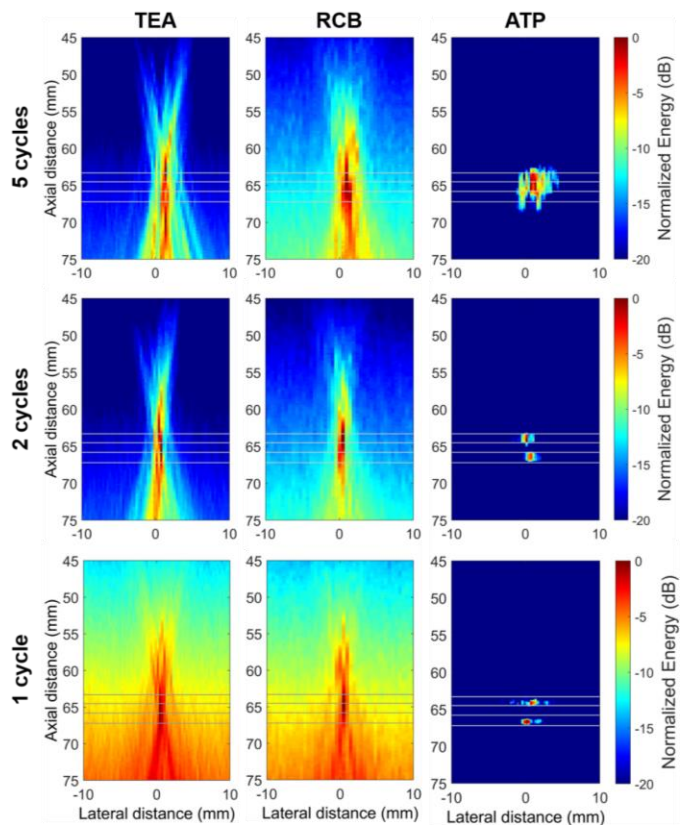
In vitro passive acoustic energy maps of microbubbles within two thin tubes exposed to 5-, 2- and 1-cycle wavelets. Microbubbles were injected through two thin silicone tubes (0.28 mm internal diameter and 0.61 mm external diameter) at approximately 2.5 mm axial separation and sonicated by 1-MHz center frequency pressure cycles with a beam focus at the axial midpoint of the two thin tubes. The resulting cavitation emissions were captured by a 128-element L7-4 linear array, which was embedded in the center of the ultrasound transducer. Axial distances refer to the distance from the linear array. The captured sensor data for 5, 2 and 1 pressure cycles was reconstructed independently using time exposure acoustics (TEA), robust Capon beamformer (RCB) and axial temporal position (ATP) passive acoustic mapping algorithms. The four horizontal lines show where the two thin tubes are located based on the B-mode image and have been overlaid with the TEA, RCB, and ATP reconstructions for 5, 2 and 1 pressure cycles.
